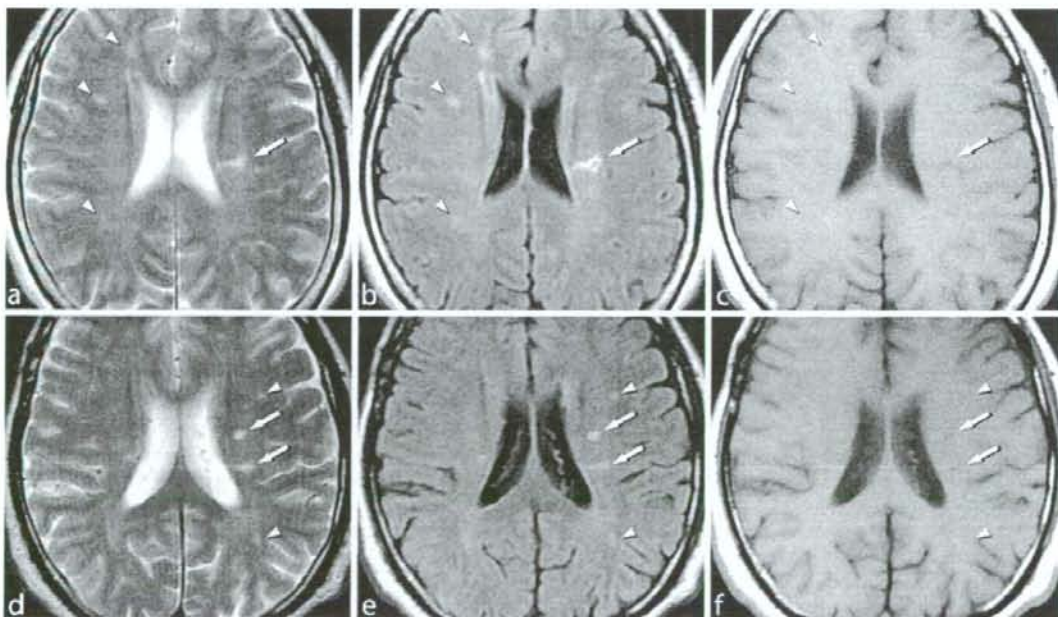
Cerebral magnetic resonance images of the small white matter infarction and mild deep white matter hyperintensity (DWMH). a–c Fifty-nine-year-old man; d–f 63-year-old woman; a, d T2-weighted images (T2WI); b, e fluid-attenuated inversion recovery (FLAIR) images; and c, f T1-weighted images (T1WI). Infarctions show marked
